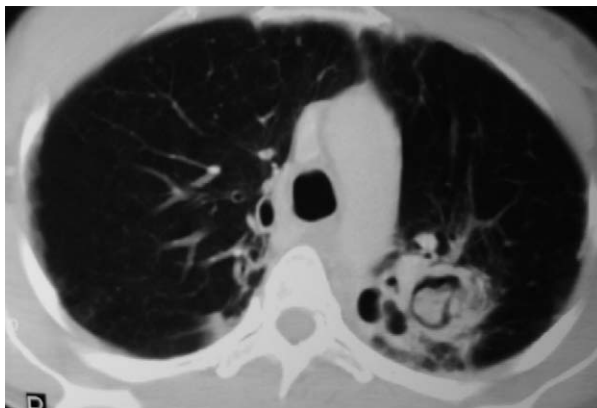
Computed tomography scan of thorax showed fungal ball involving left apicoposterior lobe.
